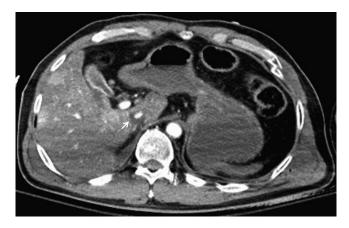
Contrast-enhanced abdominal computed tomography (CT) of a 36-year-old male patient. The halo sign (arrow) is evident. In addition, there is hyperenhancement of the gallbladder wall.
